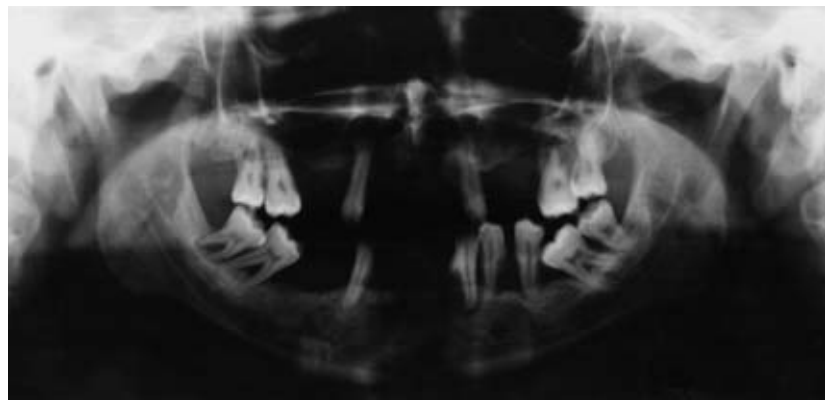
Case B: panoramic radiograph of the situation in 2000, showing furcation involvement in most of the molars, and a generalised pattern of advanced bone loss.
